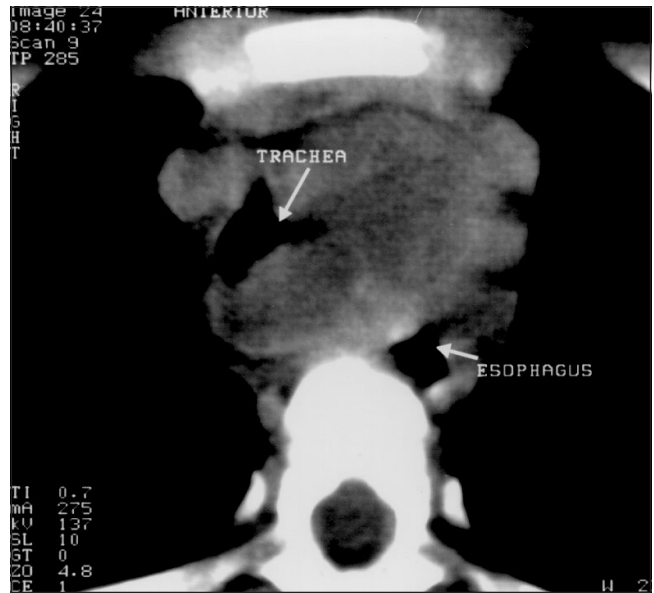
Chest radiograph on initial presentation of the patient. Note the large mediastinal mass, with deviation of the trachea to the right as well as deviation of the esophagus to the left
